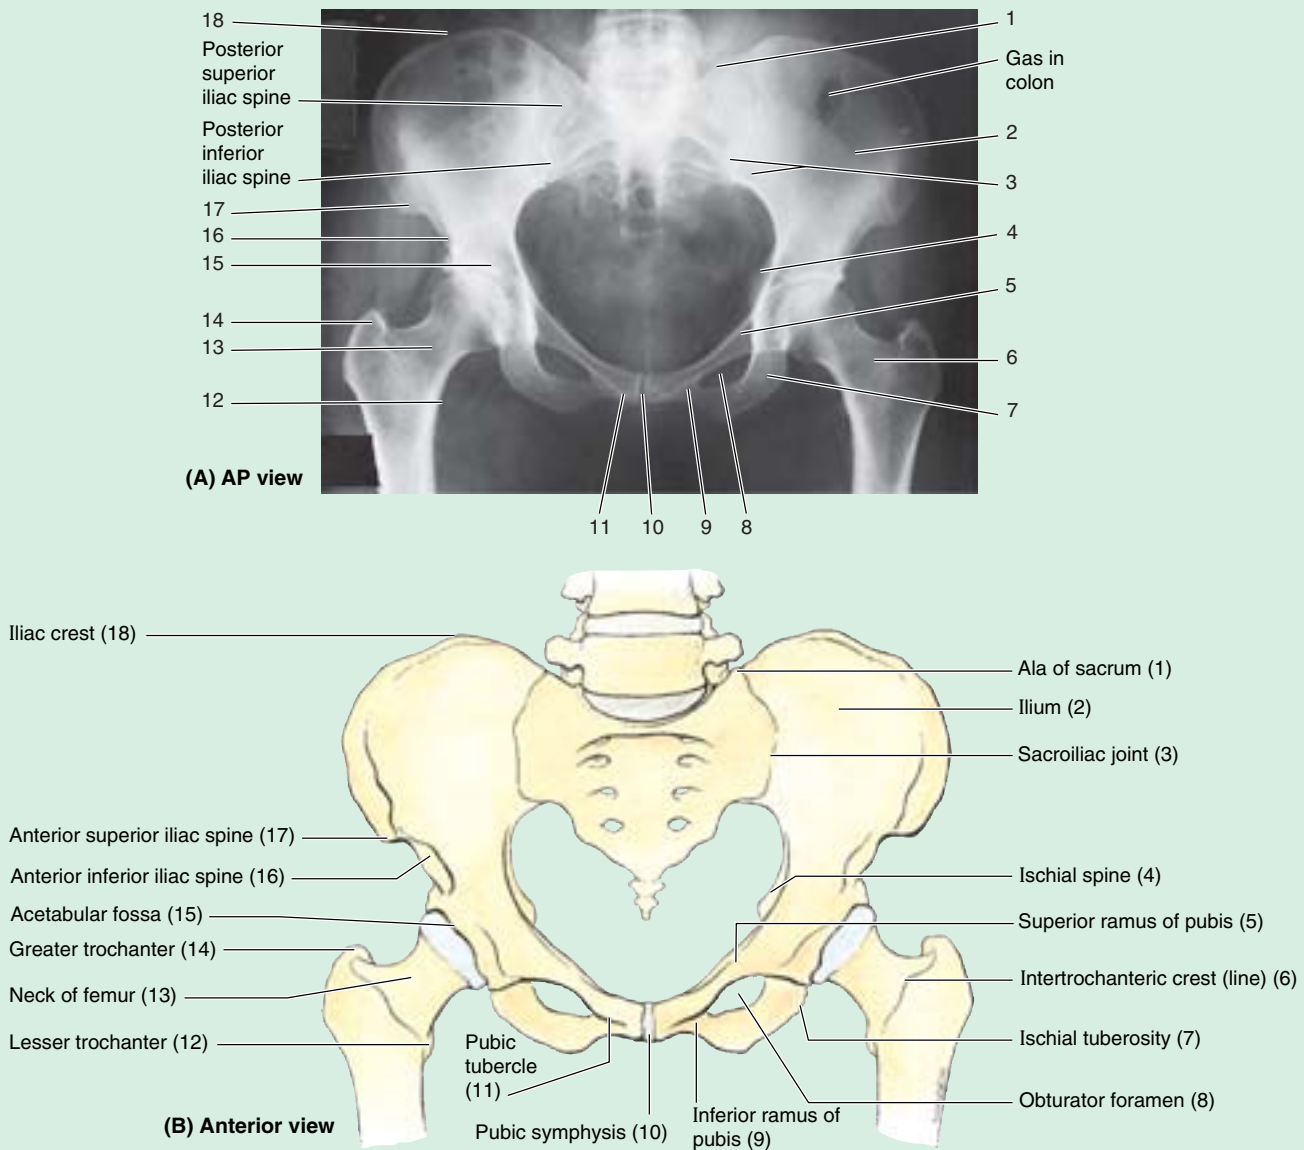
Radiograph of pelvis. A. This female pelvis demonstrates a wide subpubic angle and separation of the ischial spines. (Courtesy of Dr. E. L. Lansdown, Professor of Medical Imaging, University of Toronto, Toronto, ON, Canada.) B. The bony pelvis.
